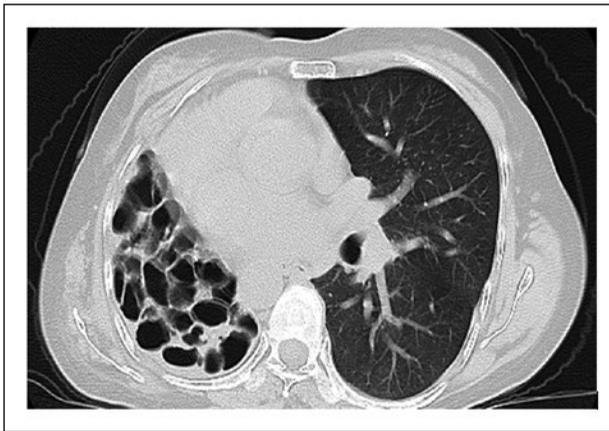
Chest CT - right lung lesion.
